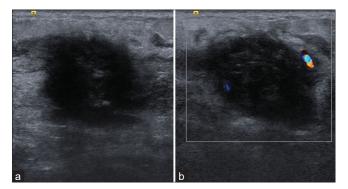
A 58-year-old male with a painless palpable mass in the left lateral breast, subsequently diagnosed with mammary Rosai-Dorfman disease. (a) The ultrasound without Doppler of the lower outer quadrant of the left breast reveals an irregular microlobulated hypoechoic mass measuring $3.4 \times 1.8 \times 3.3$ cm, located at the 4:00 position and approximately 6 cm from the nipple. (b) The ultrasound with Doppler of the lower outer quadrant of the left breast shows mild internal and peripheral vascularity associated with an irregular microlobulated hypoechoic mass, suggesting a possible malignancy or tumor.
